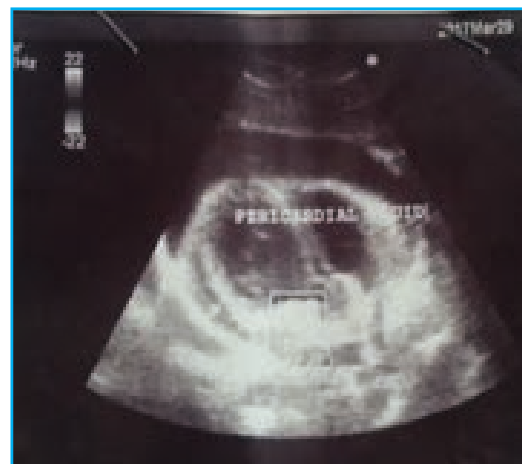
Ultrasound scan of heart showing fluid collection in the pericardial space
